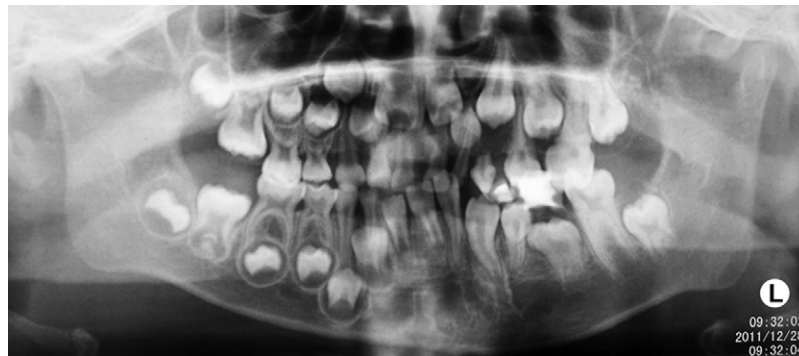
Panoramic radiograph shows generally accelerated root formation (23-27, 31-37) and eruption (24, 26, 31-37) on the left side. Early calcification of 28 could be observed, whereas 18 is not seen. Macrodontia could be observed in 26 and 36, in which the roots are elongated and the apices have almost completely formed. Age-appropriate primary dentition is observed on the right side.
